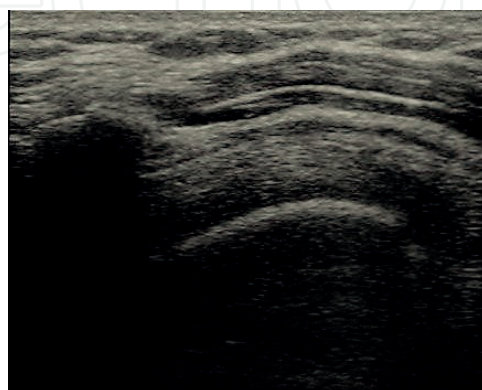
Subacromial bursitis: ultrasound imaging.
